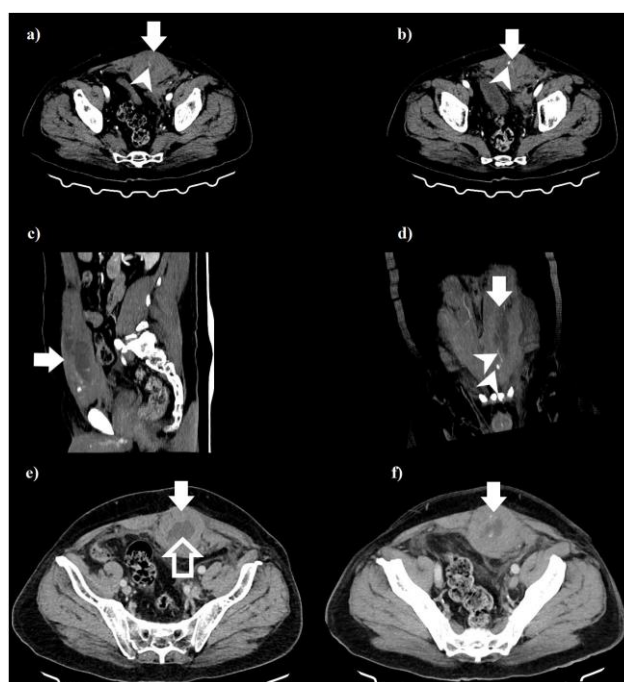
Abdominal CT scan with contrast showing the hematoma (white arrows) in the left rectus abdominis muscle, extravasation of contrast (white arrowheads) and the collimation (unfilled white arrow, the darker area inside the hematoma): a) to d) arterial phase; e) and f) venous phase
